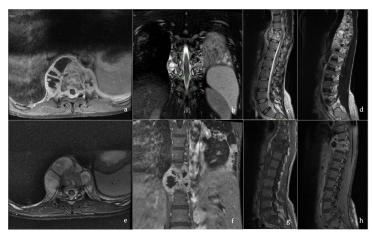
Pre-operative magnetic resonance imaging (MRI) of the spine: A) T2-axial view; B) T2-coronal view; C- D) T2-sagittal view; E) T1-axial view; F) T1-coronal view; G) and (H) T1-sagittal view (Fondazione Policlinico Universitario Agostino Gemelli IRCCS, 2022)
